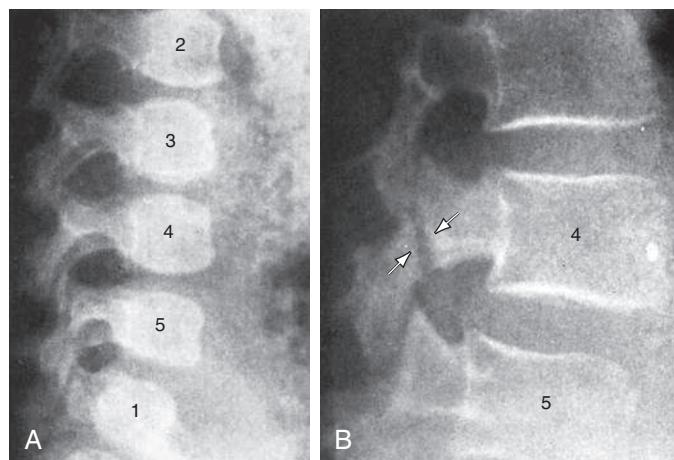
A, Normal spine at 9 months of age. B, Spondylolysis in the L4 vertebra at 10 yr of age. (From Silverman FN, Kuhn JP. *Essentials of Caffrey's Pediatric X-ray Diagnosis*. Chicago: Year Book Medical Publishers; 1990:94.)
